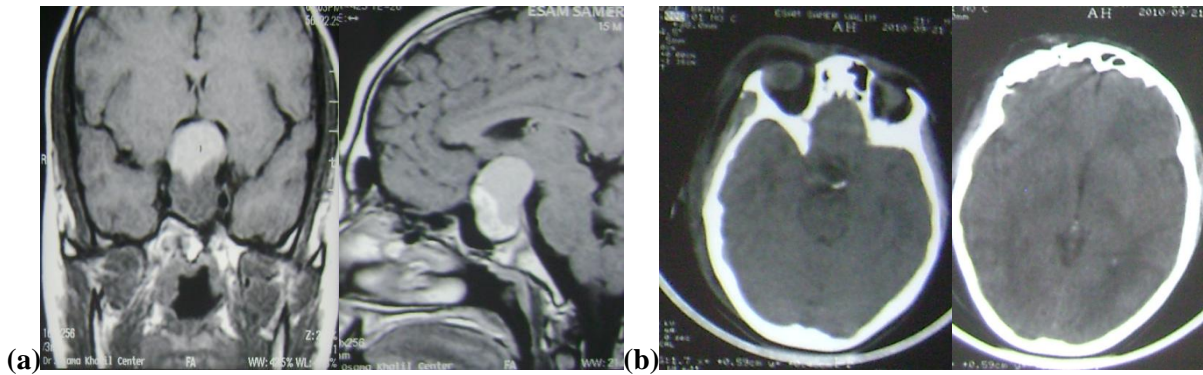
[a] preop. MRI shows craniopharyngioma, [b] CT 3 days postop., [c],[d] patient positioning., [e] bone flap,[f] MRI 2 weeks postop, [g] MRI, CT one month after completion of radiotherapy course, [h] patient 3 days after surgery, [i],[j] patient 3 month after surgery.
